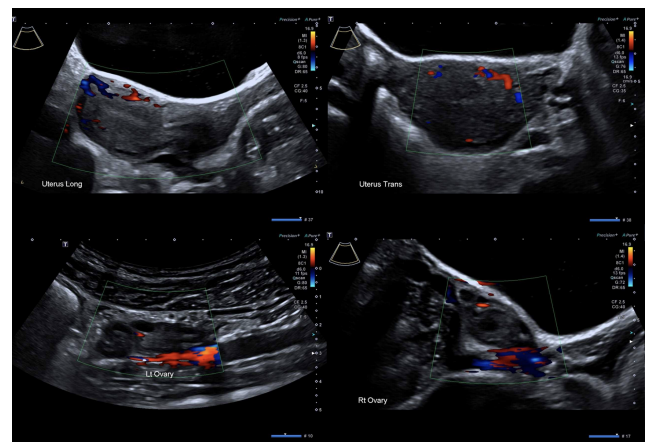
Ultrasound of the Pelvis from December 2020.
